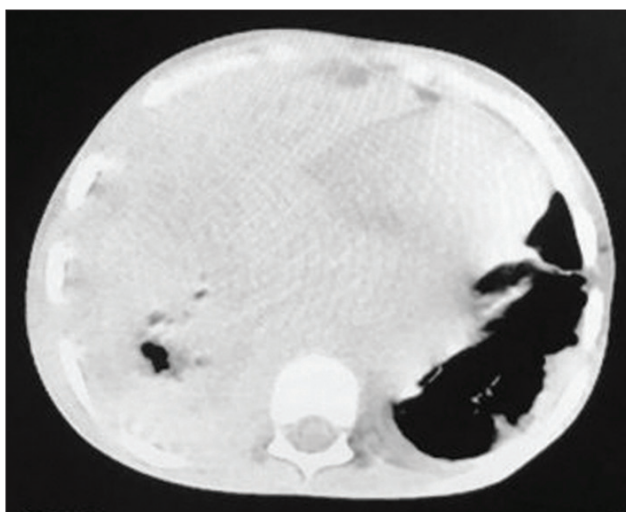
CT scan revealed variable sized masses in the right upper lobe and and both lower lobes, big mediastinal mases and the masses displayed central necrosis
